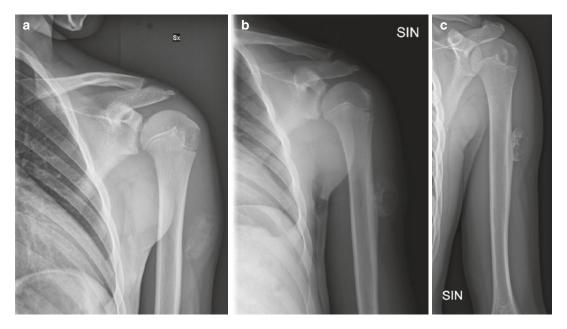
(a, b, c) Evolution of myositis ossificans on standard X-ray. (a) X-ray at 3 weeks after clinical onset shows soft tissue calcification in the left arm, (b) X-ray at
